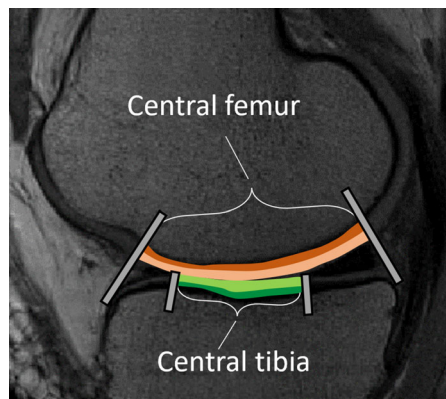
Sagittal T2-weighted image of tibiofemoral joint. ROI are color-coded: central femur (brown), central tibia (green). Lighter color indicates superficial (s) and darker color deep (d) cartilage. Bulk (b) cartilage contains both superficial and deep segments.
